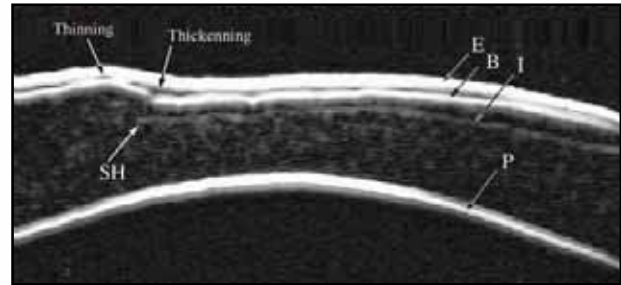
Horizontal VHF digital ultrasound corneal B-scan through the visual axis of the left cornea of a patient in whom a slightly short flap was created and the ablation was carried out. The surface of epithelium (E), Bowman's layer (B), the keratectomy interface (I), and the endothelium (P) are labeled. The abrupt termination of the keratectomy producing a short hinge is shown (SH). Lack of ablation nasal to this has produced a large step in the cornea. The stromal surface step is partially compensated for by epithelial remodeling; the epithelium characteristically thins over the "bump" while thickening in the crevice produced. This cross-section clearly demonstrates why topography-guided ablations (or even wavefront-guided ablations, which are 70% biased to the front surface) will not be fully successful in correcting the stromal irregularity.
